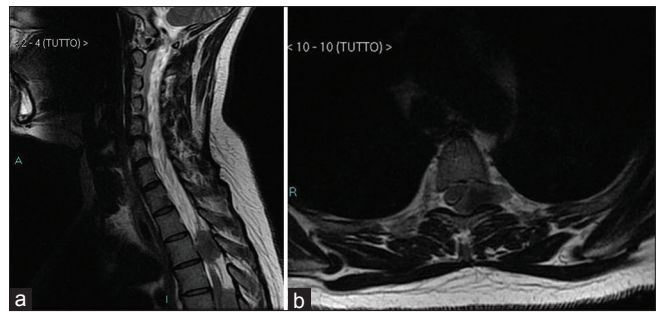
(a) Sagittal magnetic resonance (MR) image showing an enhancing extramedullary mass located between D3–D4 vertebral levels; (b) axial MR image showing an enhancing extramedullary mass with spinal cord displacement and compression, and extending to the left D3–D4 foramen
